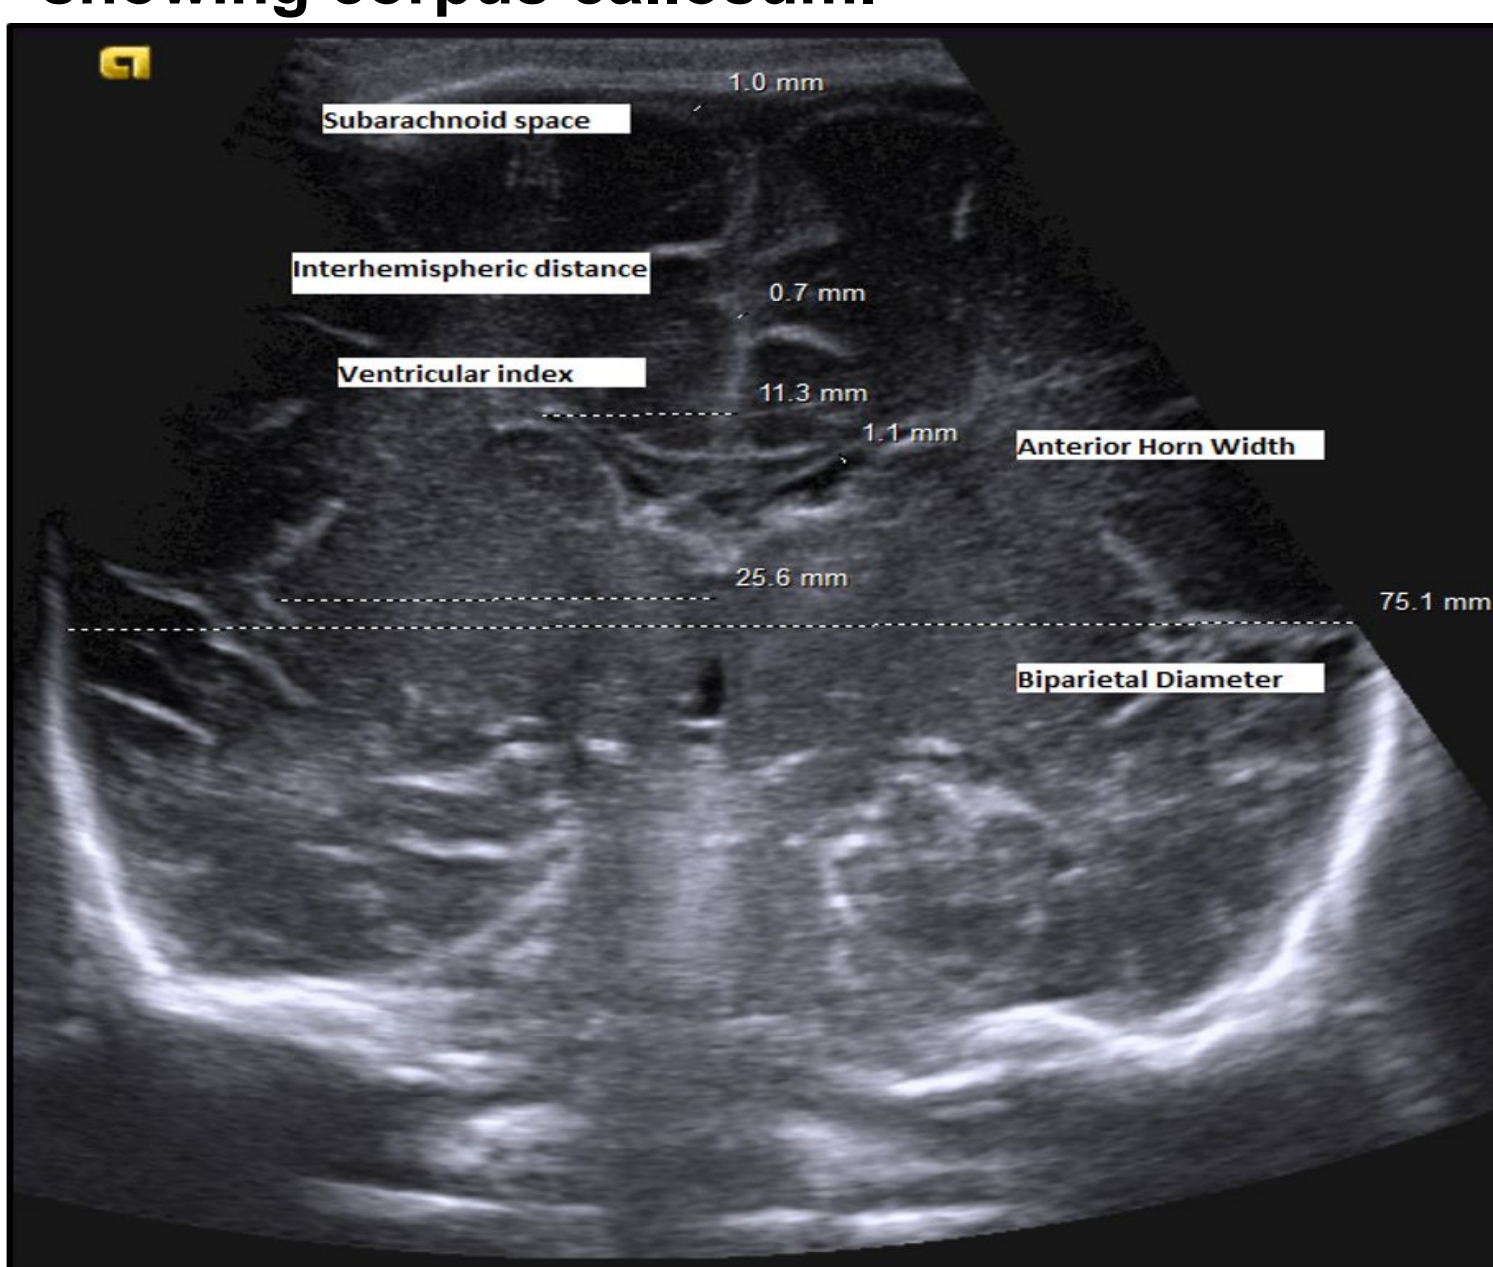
Cranial Ultrasound - Coronal Section
